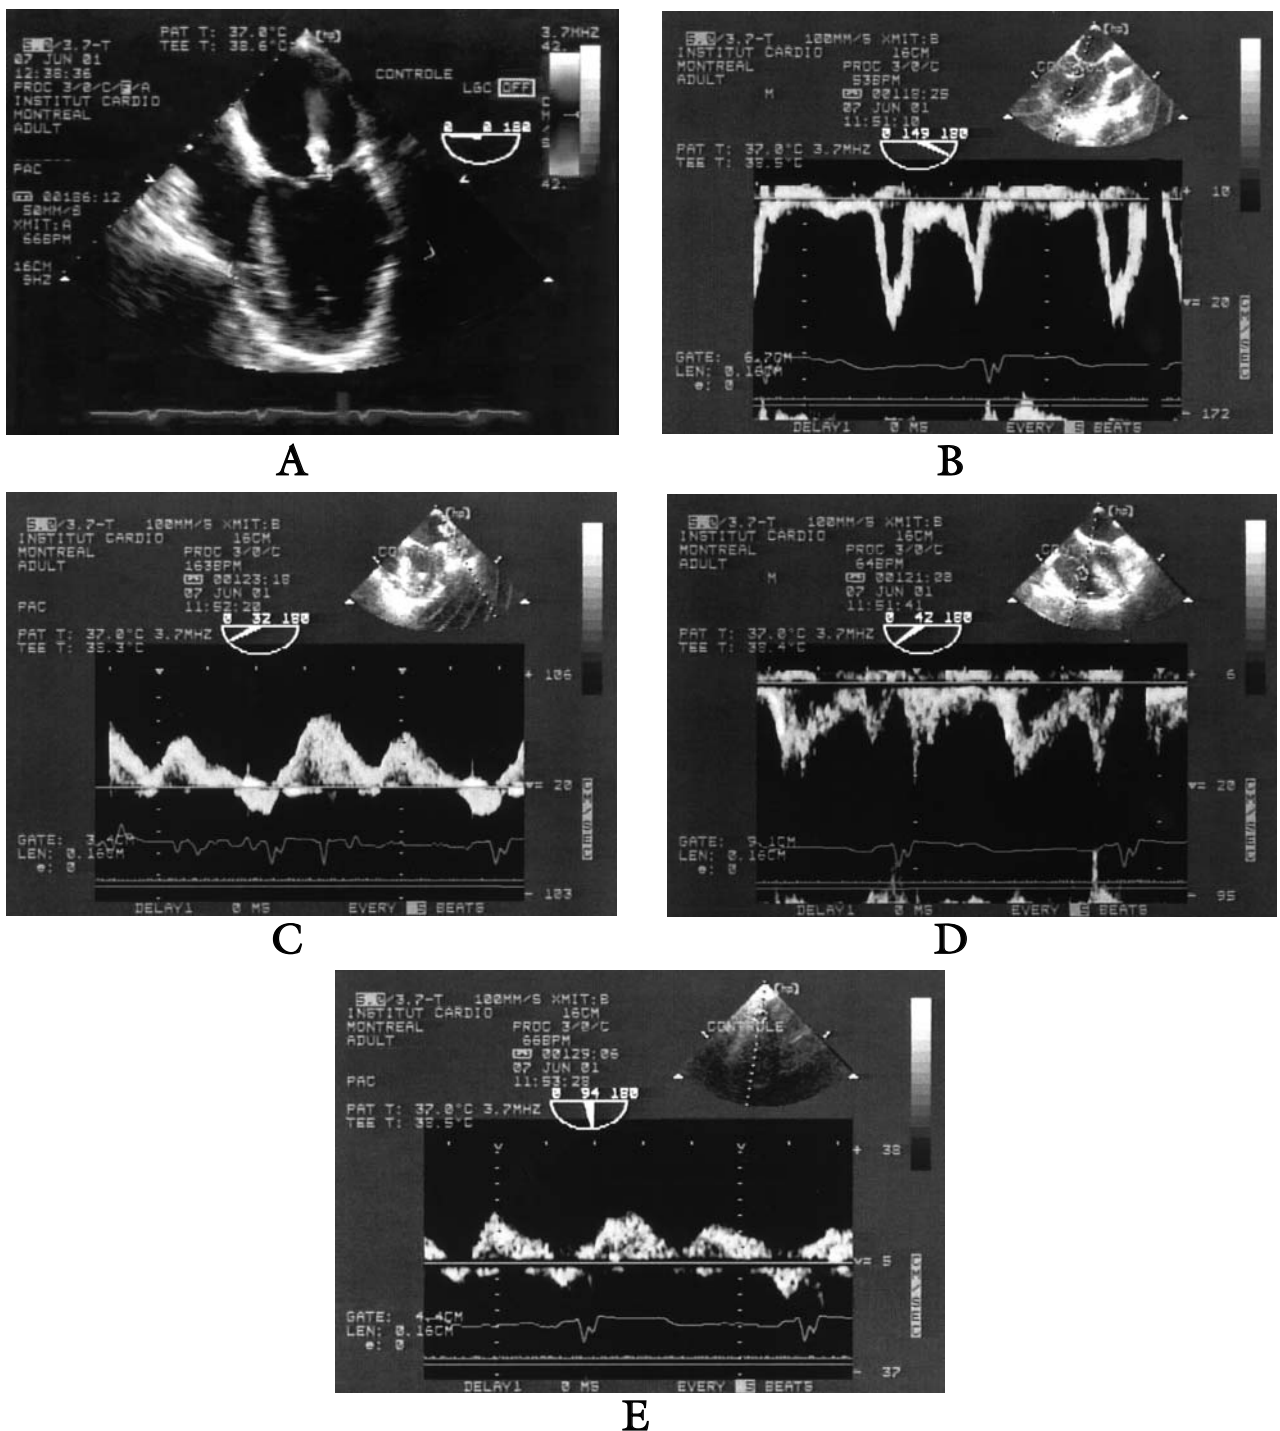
Transesophageal echocardiography findings after anesthetic induction. Findings were compatible with a normal right and left diastolic function. A) Mild mitral regurgitation; B) mitral flow: E and A wave velocities were 86.2 and 73.1 $\text{cm}\cdot\text{sec}^{-1}$ respectively (E/A ratio = 1.18); E wave deceleration time was 200 msec; C) pulmonary venous flow systolic and diastolic wave velocities were 60.9 and 45.2 $\text{cm}\cdot\text{sec}^{-1}$ respectively; D) tricuspid flow E and A wave velocities were 37.8 and 37 $\text{cm}\cdot\text{sec}^{-1}$ respectively (E/A ratio = 1.02); E) hepatic flow systolic and diastolic wave velocities were 15.3 and 11.3 $\text{cm}\cdot\text{sec}^{-1}$ respectively.
